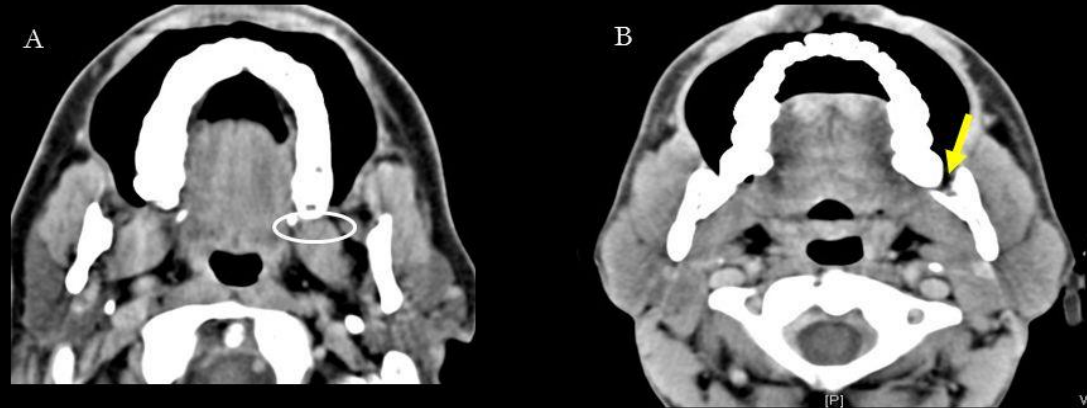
Axial CT sections, A. shows the upper limit of RMT behind the maxillary tuberosity (ellipse)
